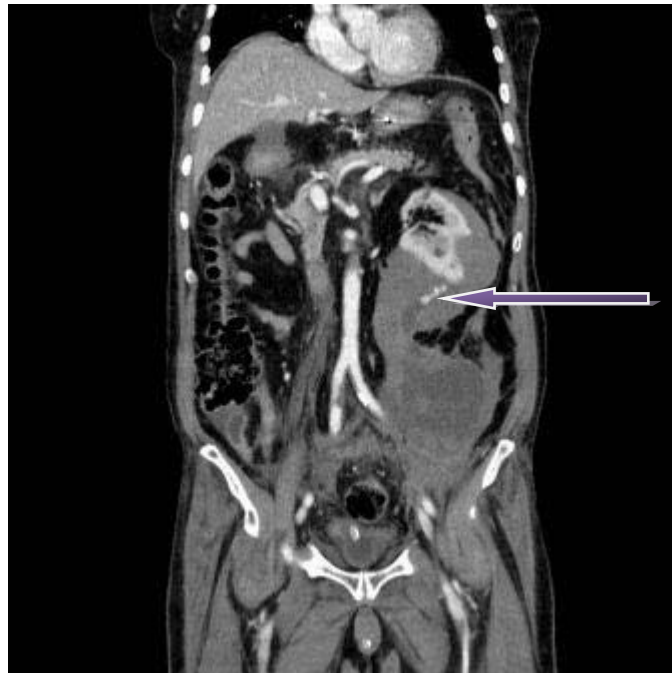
CT scan with IV contrast , coronal view (Porto venous phase) showing the extravasation of the contrast (the arrow) indicating active bleeding
